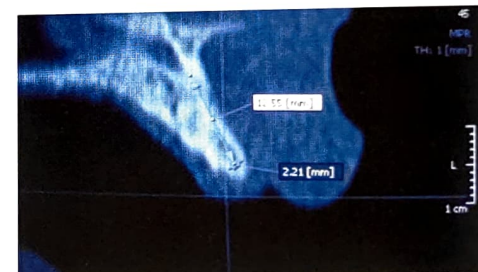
Computed tomography scans. a) axial view, b) sagittal view
